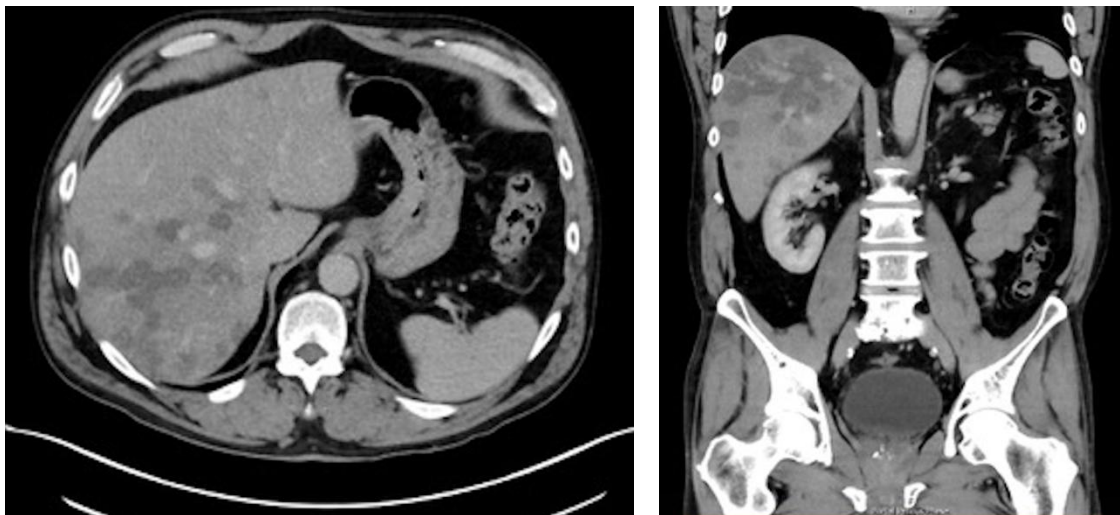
Abdominal contrast-enhanced computed tomography scan showing multiple liver hypodense lesions
